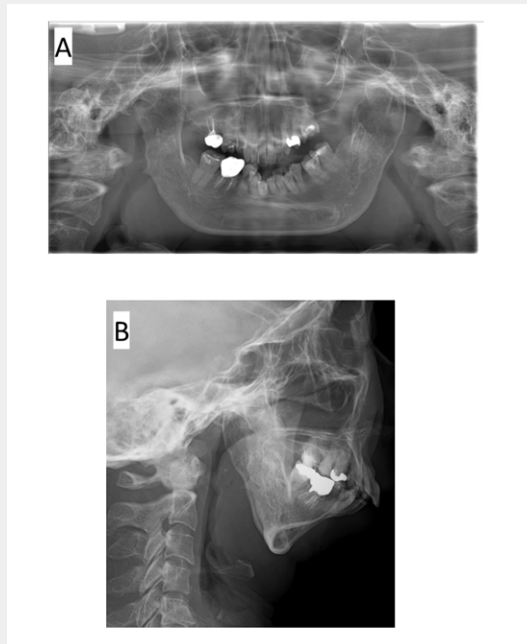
Panoramic and cephalometric radiographs. Abnormal mandibular morphology and bony adhesions between the maxilla and the mandible are observed. Cephalometric X-P shows inferior growth of the mandible and an obvious narrowing of the airway.
